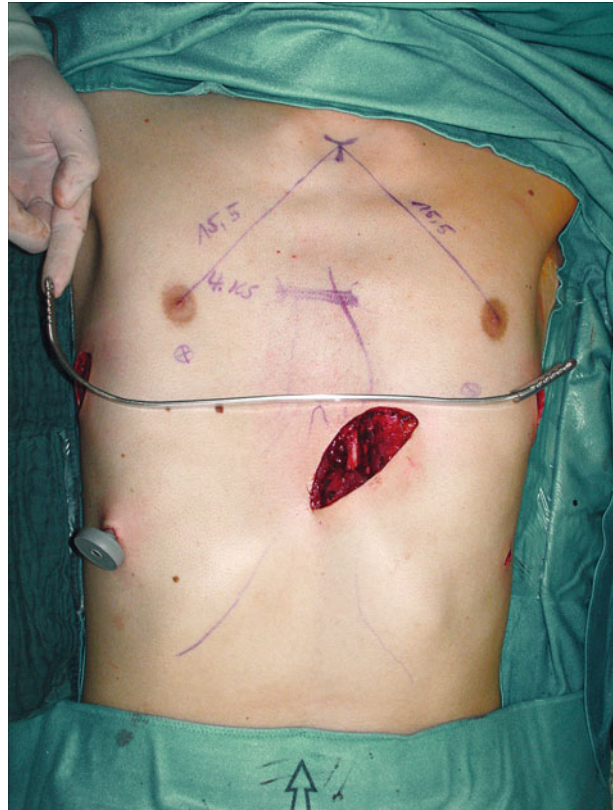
Intraoperative view with already performed relaxing sternochondroplasties via the left parasternal incision. The shaped pectus bar placed into the desired direction above the skin. The endoscopic ports placed at the lower rib arches, ready for insertion of the endoscope
